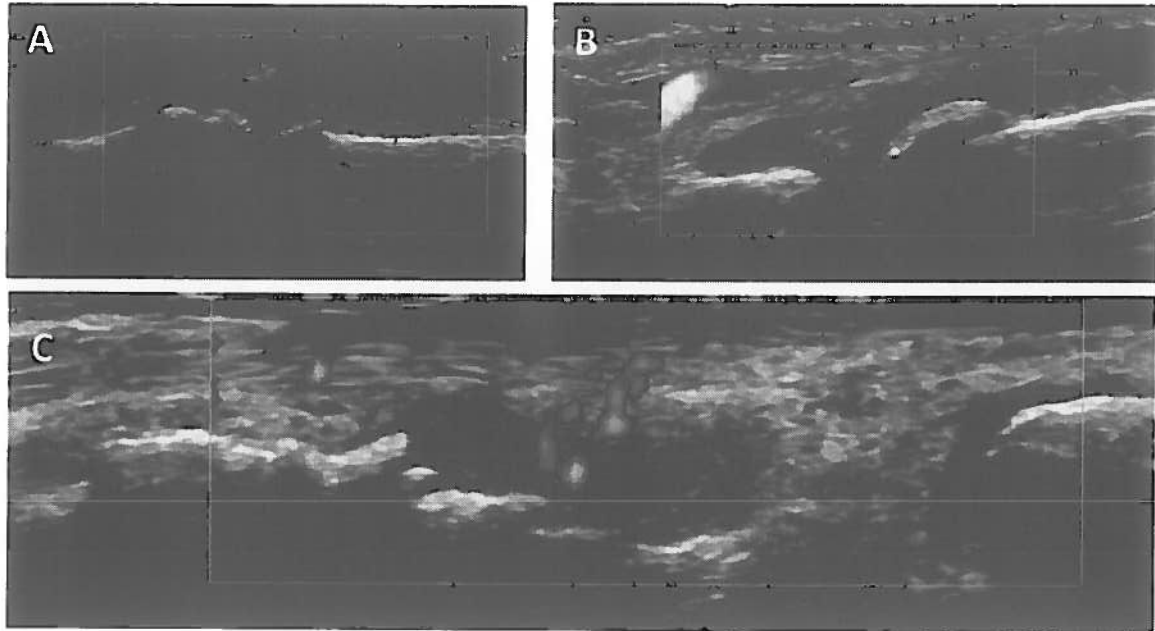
Ultrasound features of hand OA:
